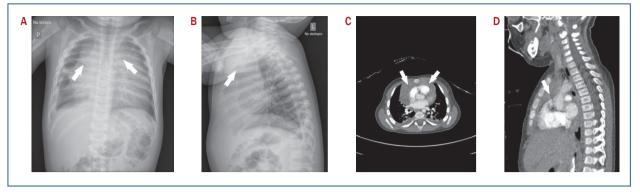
Chest X-ray posterior-anterior (P-A); huge central shadow, up to 13 cm wide, blurred heart silhouette (arrow); B. Lateral chest X-ray; greatly widened shadow anterior mediastinum (arrow); C, D. Chest computed tomography (CT); thymus changed without calcifications, heterogeneously reinforced; dimensions 66 × 26 × 78 mm, does not show features od mediastinal and tracheobronchial tree modeling (arrow)
